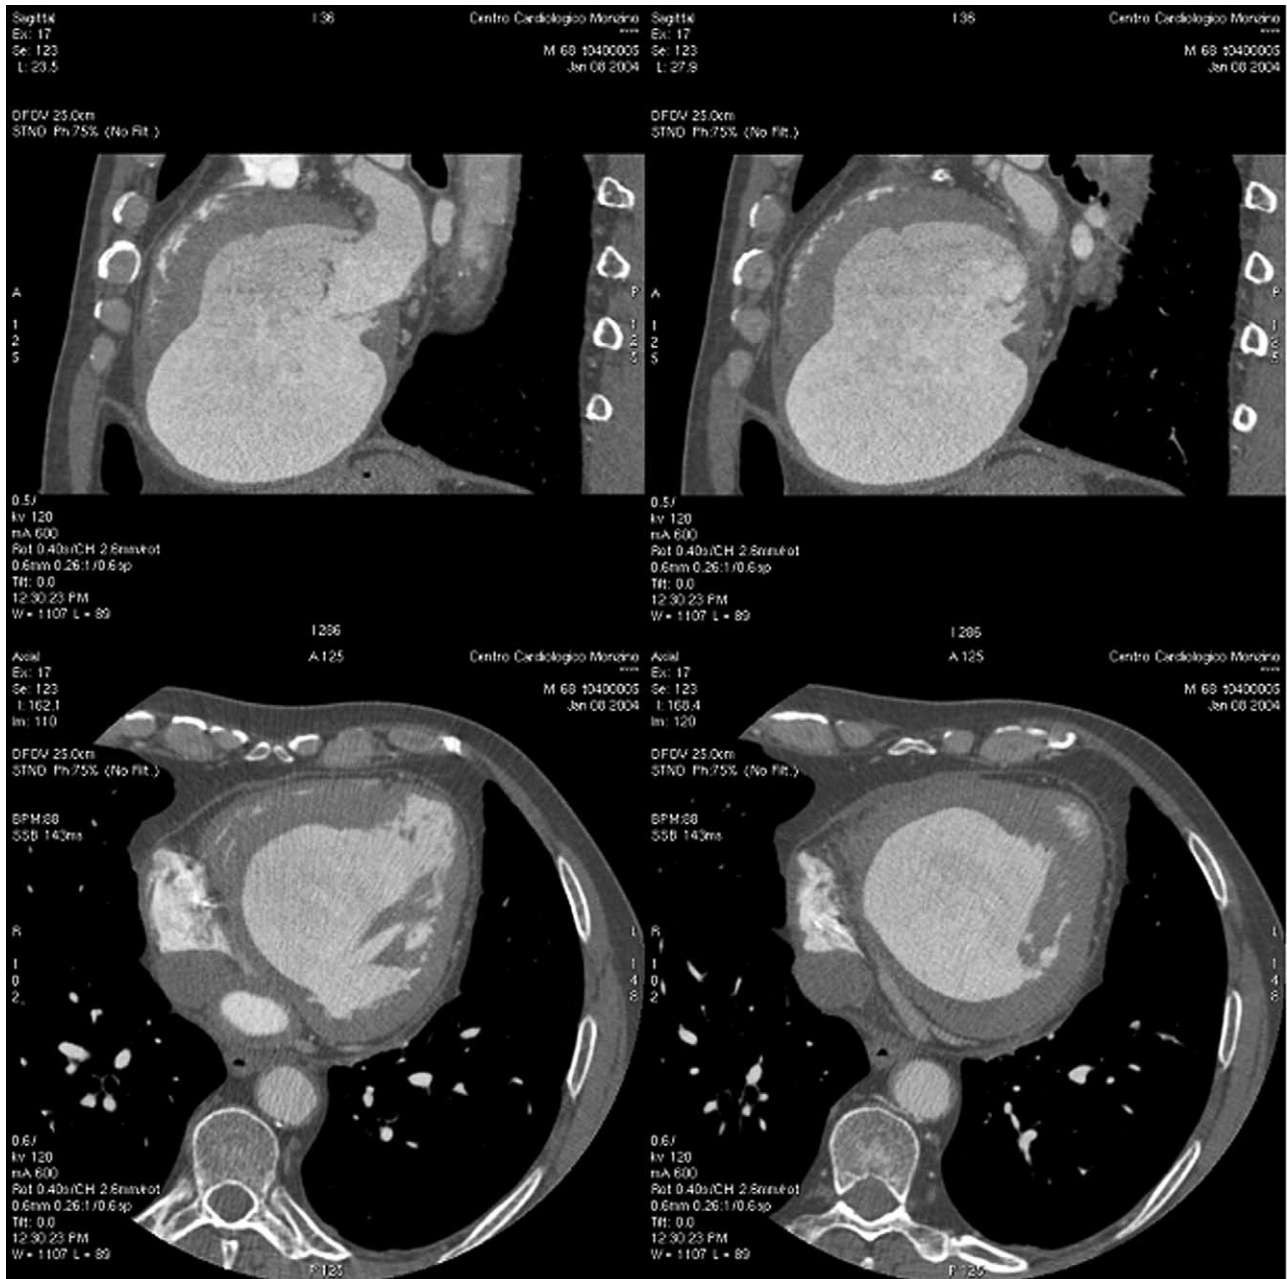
Long axis view (upper) and axial view (lower) of the aneurysm by multidetector computed tomography (MDCT).
